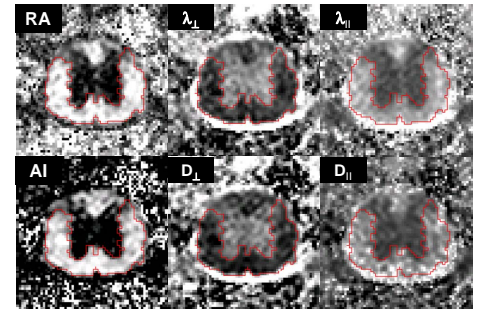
six-direction DTI vs. two-direction DWI of control cord. ROIs are based on the six-direction DTI maps.
